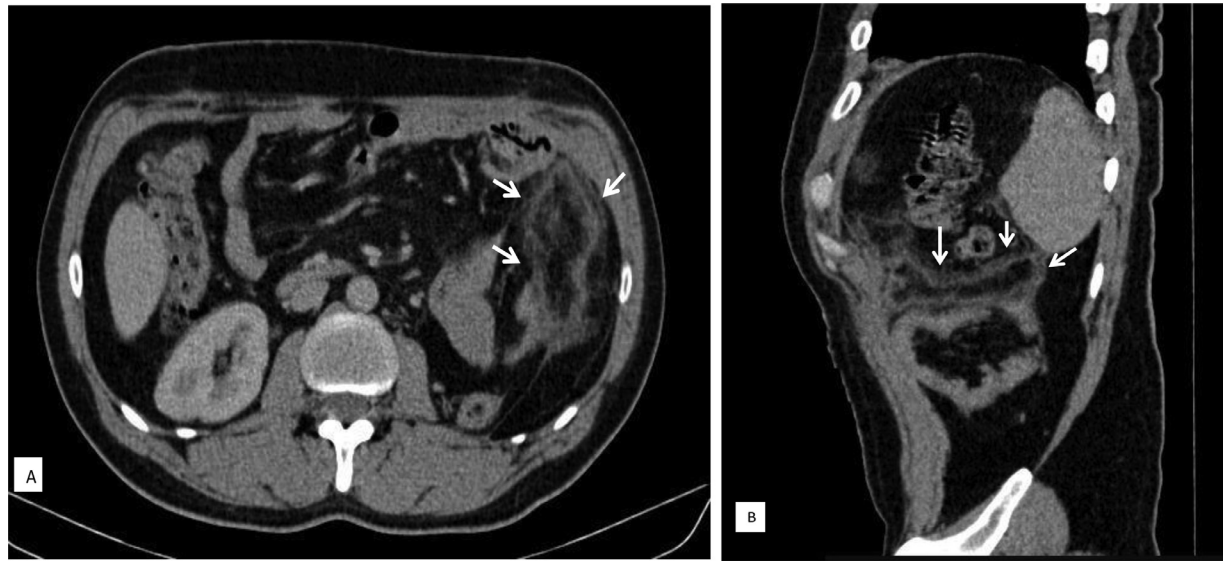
Contrast-enhanced abdominopelvic computed tomography image (A: axial, B: sagittal), showing an oval shaped hyperdense rim with hyperattenuating streaky infiltration is seen between the descending colon and the left peritoneum (white arrow).
